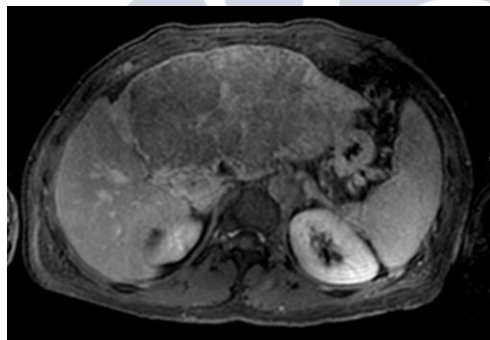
Axial slice from an MRI image of a hepatic carcinoma, granted by the Department of Radiology, University Hospital, Santiago de Compostela.
